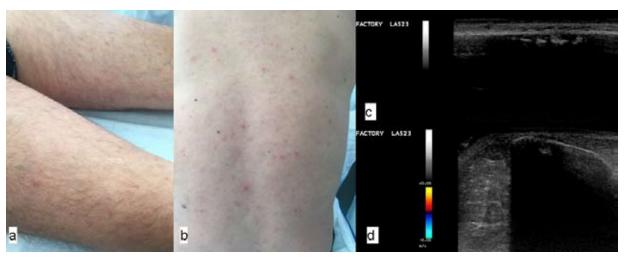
Case 2; clinical manifestations: erythematous maculo-papular rash on the limbs (a) and trunk (b); the ultrasound examination: thickening of the compact tibial bone associated with subperiosteal destructive and proliferative changes (c); (d)
